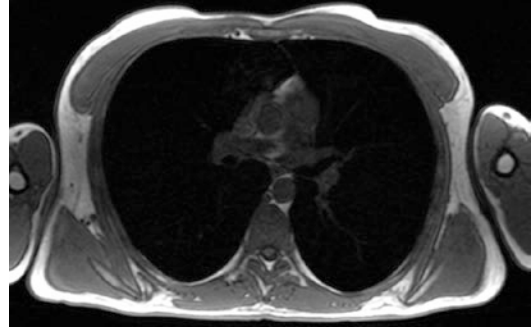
T1-weighted volumetric interpolated 3D gradient echo sequence (VIBE, transverse acquisition in breath-hold, healthy, 30-year-old male subject)
